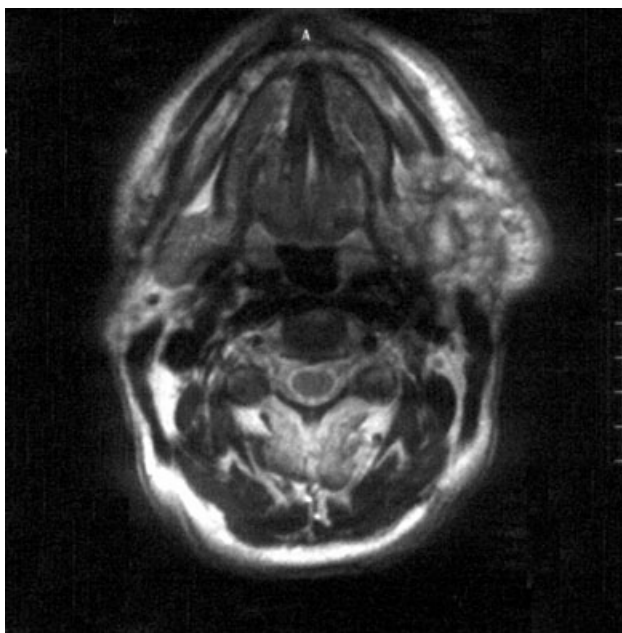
Magnetic resonance imaging at the time of diagnosis, a soft tissue density mass lesion showing infiltration to the skin in the left part of the mandible.
